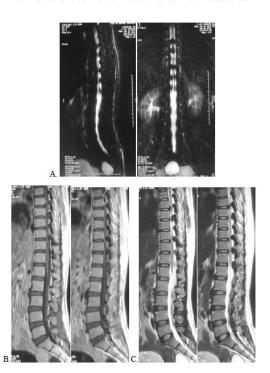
MR myelography and sagittal thoracolumbar MRI showing multiple posterior indentations and nodular hypointensities from Th6–L1 consistent with ossification of the ligamentum flavum (OLF) and spinal canal stenosis at Th7–11.
